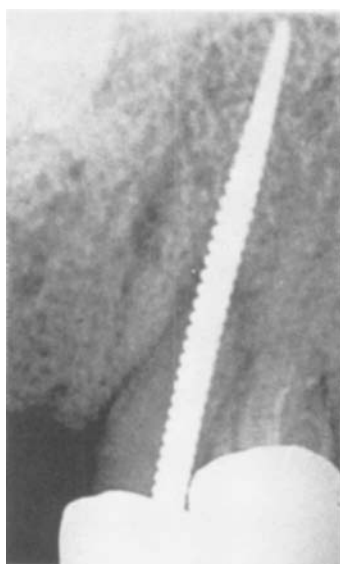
■ Postoperative radiograph of endodontic stabilization.
